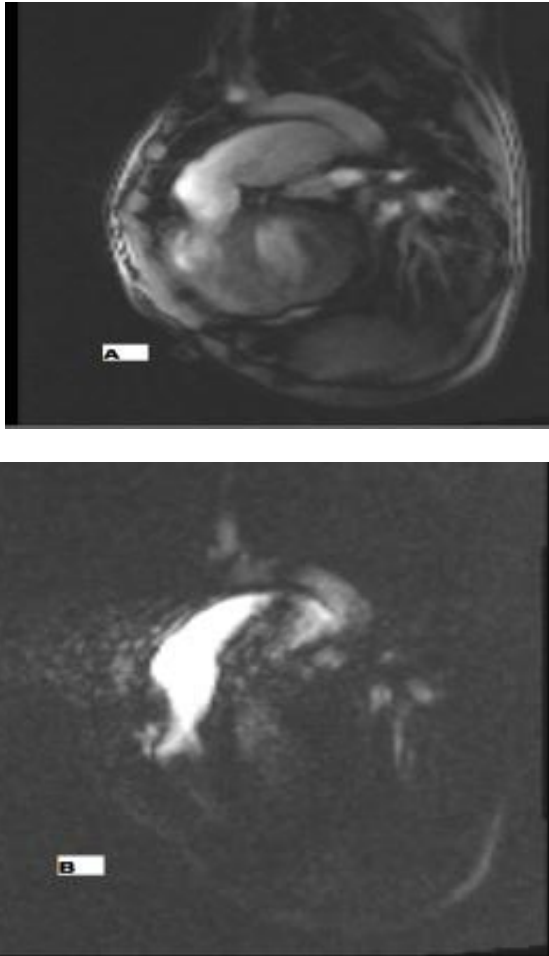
Cardiac MRI phase contrast tracing for MPA (A) MPA phase image, (B) MPA magnitude image.
